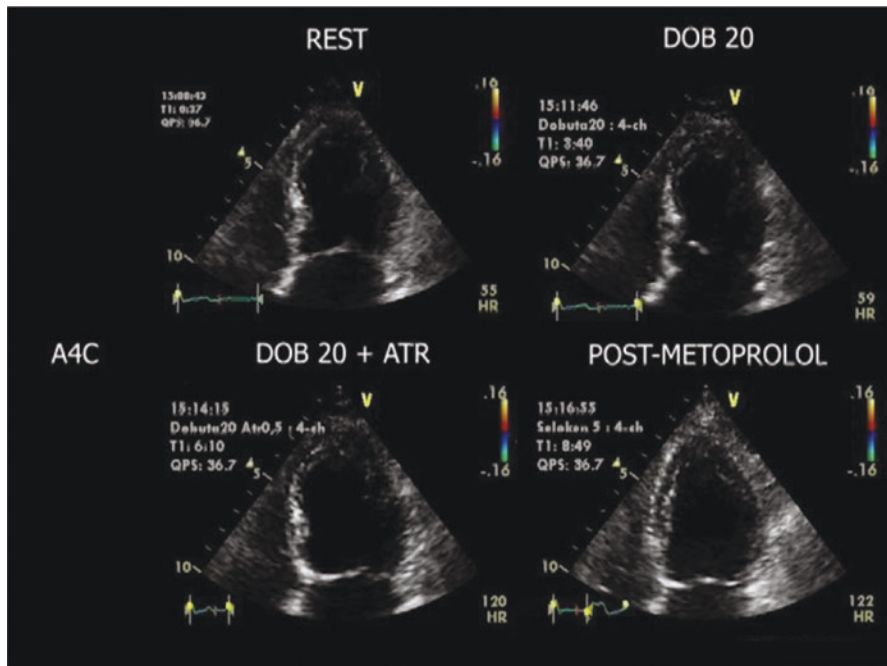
End-systolic frames showing normal wall motion at rest in the apical four-chamber view (left upper panel). DSE is positive in the lateral and latero-apical segments during the dobutamine administration (right upper panel) and more positive after atropine (left lower panel) and beta-blocker (right lower panel) administration. See the corresponding Video 18.5. (By courtesy of Dr. Dimitrios Soulis, Athens, Greece. The video is available under the chapter’s “Supplementary Material” on Springer Link)
